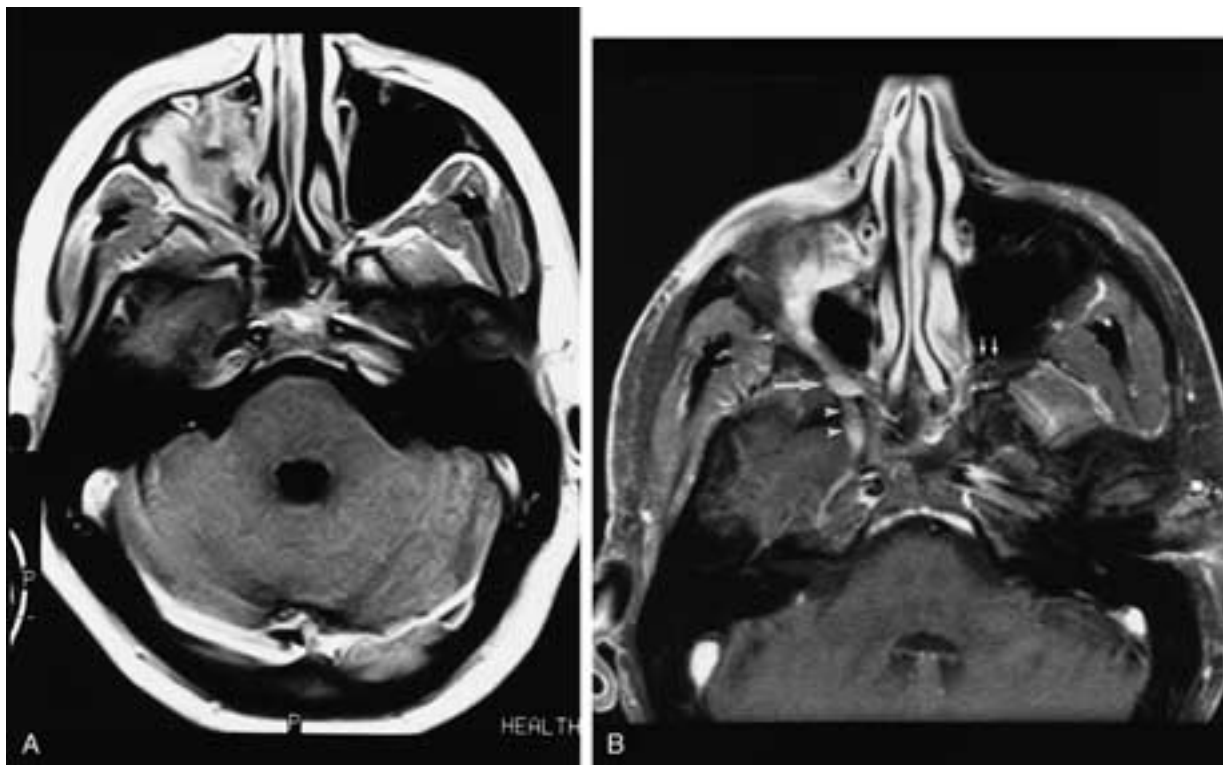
Squamous cell carcinoma in the right infraorbital region with PNS along the infraorbital branch of the maxillary nerve (V₂). A, Axial contrast-enhanced MR image without fat suppression. It is almost impossible to identify tumor within the right PPF. This scan was performed at an outside institution, and there was no precontrast T1-weighted imaging to help evaluate the PPF. B, Axial contrast-enhanced MR image with fat suppression allows visualization of excessive enhancement representing PNS in the right PPF (long arrow). Note the lack of significant enhancement in the normal left PPF (short arrows). On the right side, there is continued posterior or retrograde PNS within the foramen rotundum (arrowheads).
